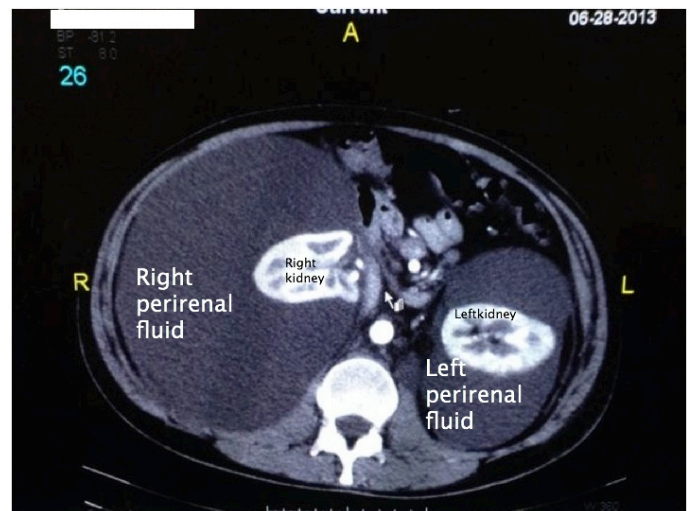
Contrast enhanced computed tomogram of the abdomen showing bilateral perinephric fluid collections, displacing normally functioning renal parenchyma within the capsule
